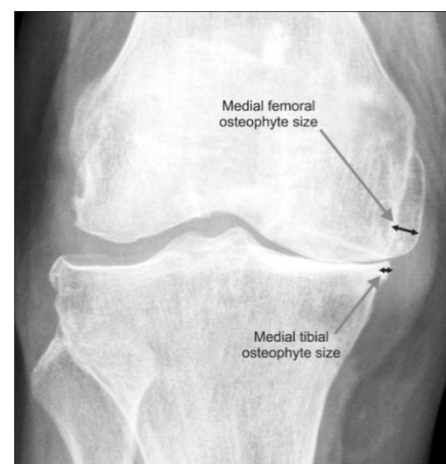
Osteophytes in a human knee as seen on a radiograph<sup>6</sup>.
